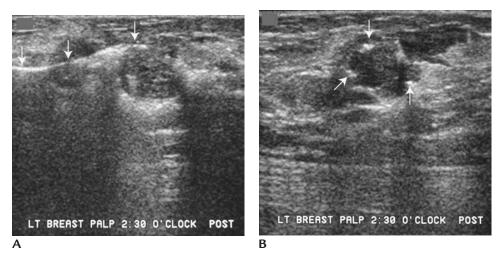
Ultrasound-guided biopsy. Mucinous carcinoma. (A) Radiofrequency cutting device (*arrows*) "entrapping" portions of mass being sample. Posterior acoustic enhancement associated with the mass a common finding with mucinous carcinoma. (B) Orthogonal view showing struts (*arrows*) of radiofrequency device in the mass.
